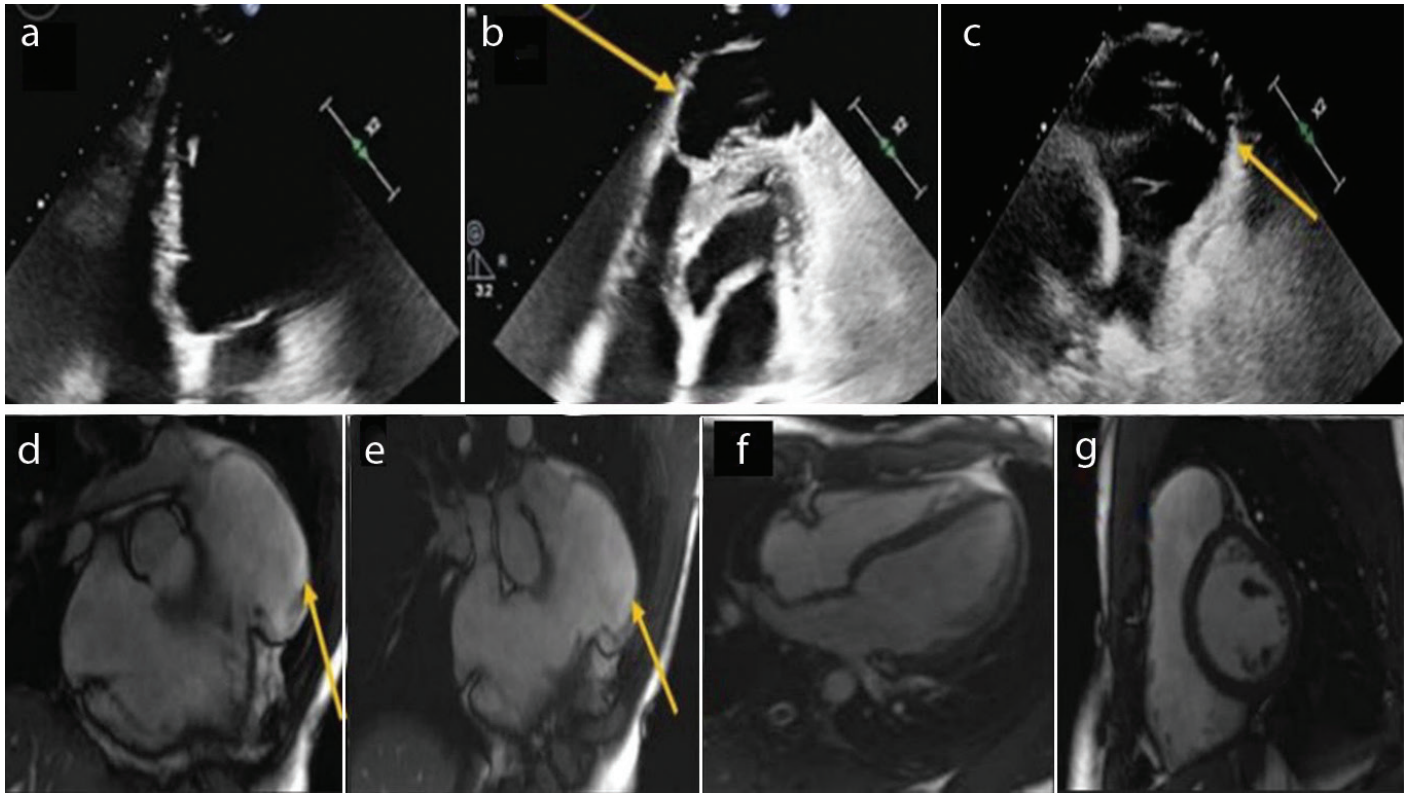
(a) Transthoracic echocardiography apical 4 chamber view depicting mildly dilated right ventricle. (b) Modified apical 4 chamber transthoracic echocardiography view identifying aneurysmatic right ventricle segment at the right ventricle apex. (c) Parasternal short axis transthoracic echocardiographic view at the aortic level demonstrating aneurysmatic right ventricular segment. (d, e) Cardiac magnetic resonance imaging right ventricle inflow-outflow CINE images at different levels visualizing large aneurysmatic formation of right ventricle apex. (f) Cardiac magnetic resonance imaging 4 chamber CINE image indicating no significant right ventricular pathology. (g) Cardiac magnetic resonance imaging short axis CINE image at midventricular level revealing no significant right ventricular pathology.
